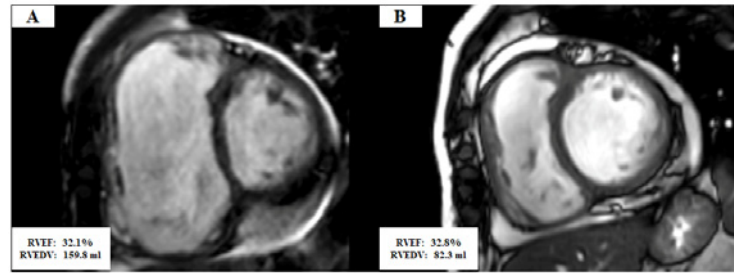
Cardiac MRI (end-diastole).
